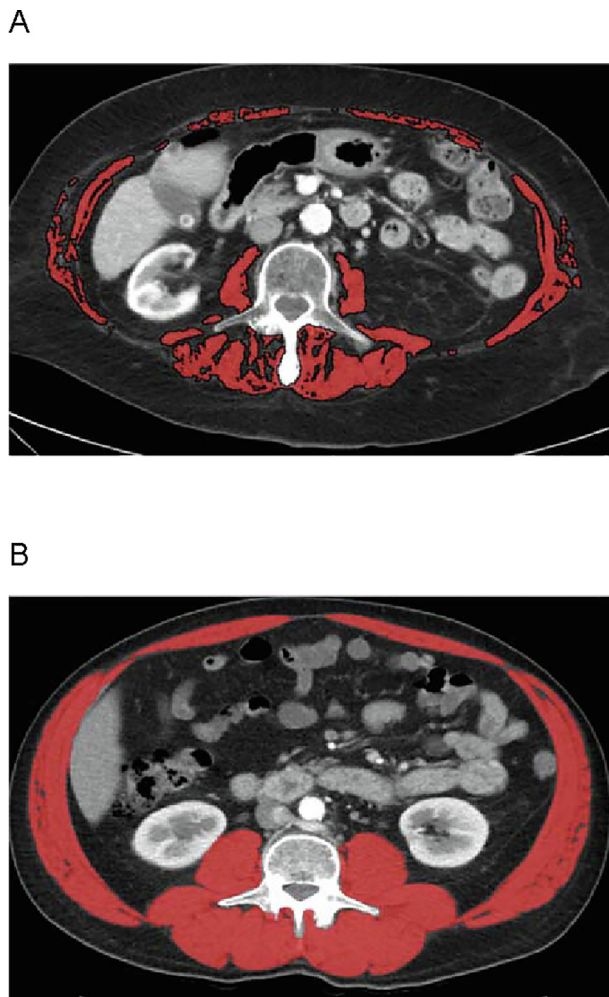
Computed tomography images at the level of the third lumbar vertebra highlighting (in red) the total skeletal muscle area (including the psoas, paraspinous muscles and abdominal wall muscles) in (A) a patient with sarcopenia and (B) a patient without sarcopenia.
